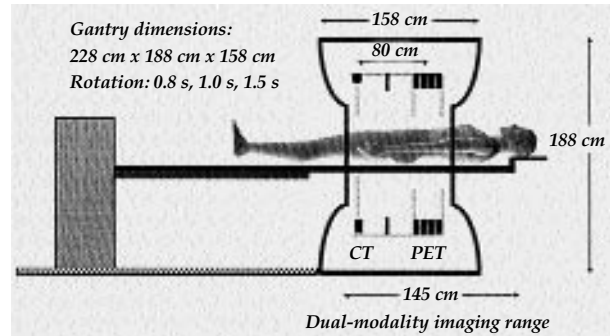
PET/CT, with courtesy of reference 1.
